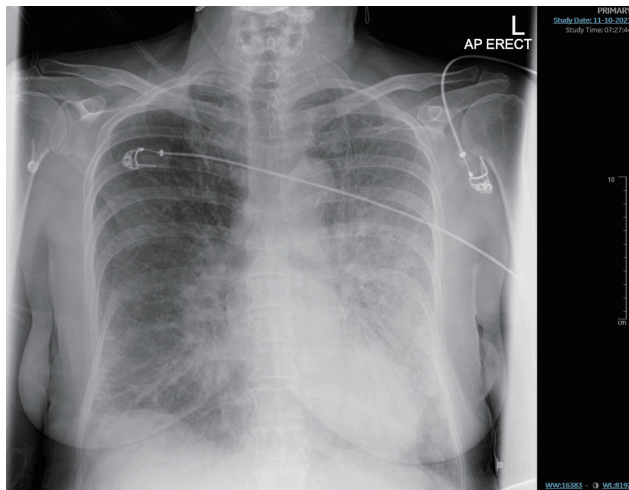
Chest X-ray showing acute pulmonary edema.
